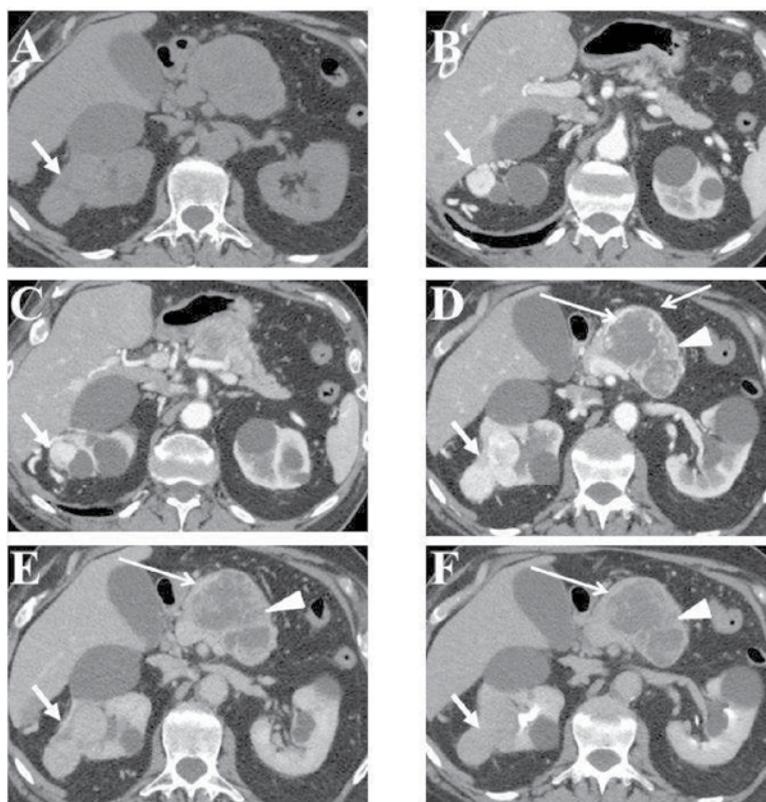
(A–F): Multidetector computed tomography imaging. Pre-contrast (A) and contrast-enhanced pancreatic (A–D), venous (E) and late (F) phases. Axial images. Multi-detector computed tomography examination showed a pancreatic body well-delimited mass (A, C–F) with maximum diameter of 80 mm, a peripheral rim enhancement (arrow), irregular low-density central areas and solid trabeculae (arrowhead), both hypoenhanced compared to the unaffected parenchyma of pancreatic tail (B) in pancreatic phase (C–D). During the portal venous (E) and delayed (F) phases, the mass remained hypodense and peripheral rim of enhancement showed wash-out. The upstream main pancreatic duct was dilated (C). Perinodular solid masses (short arrow) bulging from the upper pole of right kidney with maximum diameter of 70 mm, homogeneously hyperenhancing during pancreatic phase (B–D) with wash-out during venous (E) and late (F) phases of examination were visible. There was no evidence of local peripancreatic and perirenal invasion, liver metastasis. Superior mesenteric, splenic vessels, portal vein, and renal vessels were preserved.
